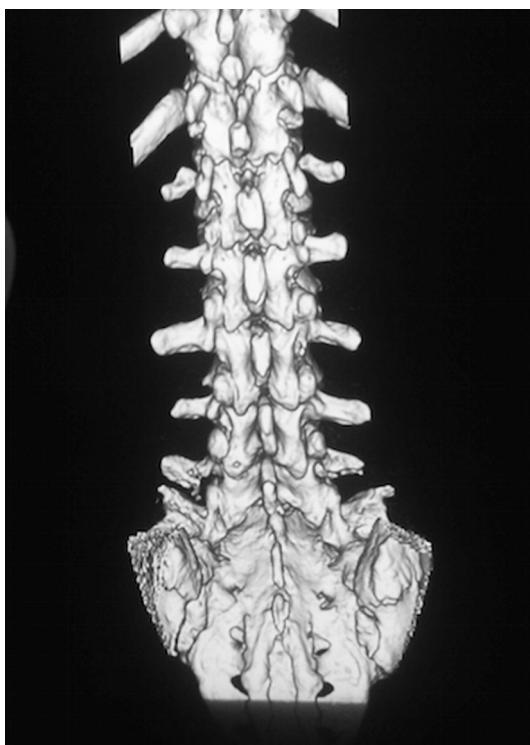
CT scan posterior view with floating lamina
